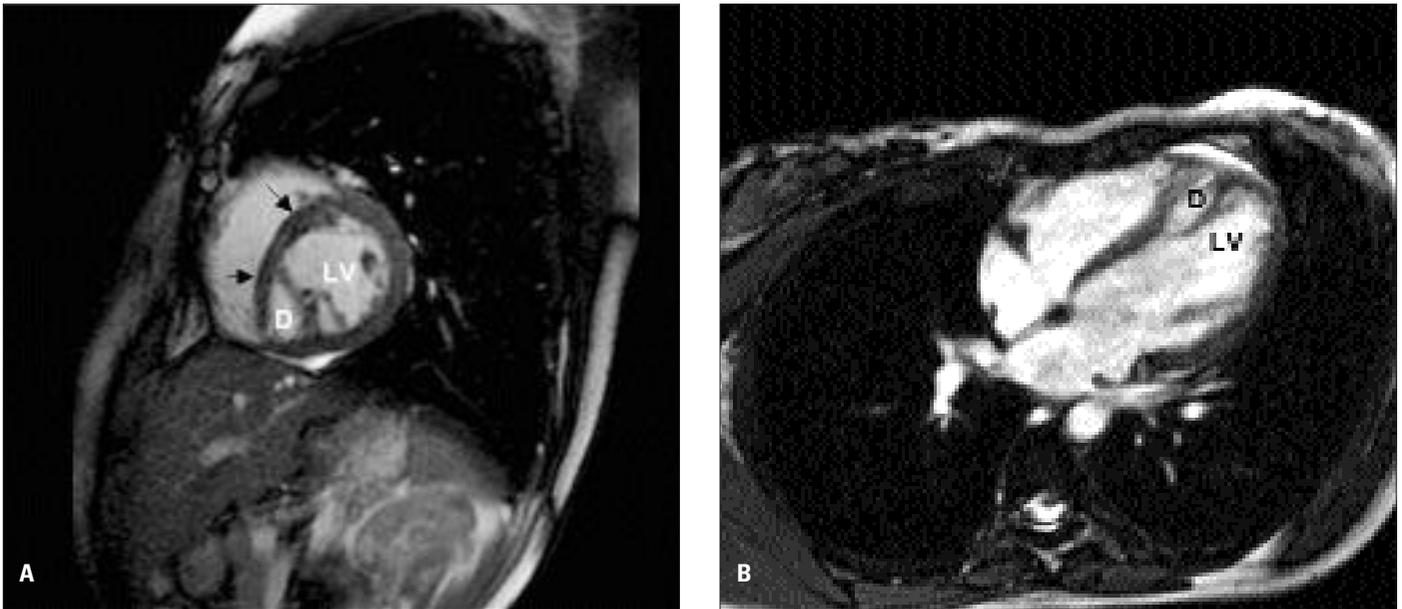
Dynamic cardiac MR images in sagittal (A) and axial (B) views shows the diverticulum originating at the apex of the left ventricle, near the interventricular septum (D: diverticulum; LV: left ventricle; MR: magnetic resonance, arrows: interventricular septum).
